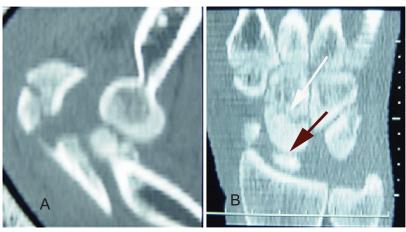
The CT scan of the elbow and wrist; A. The CT scan of the elbow (Sagittal section). B. The CT scan of the wrist (Coronal section). The thin arrow shows capitate fracture. The thick one reveals locking of the scaphoid proximal fragment between the radius and capitates.
